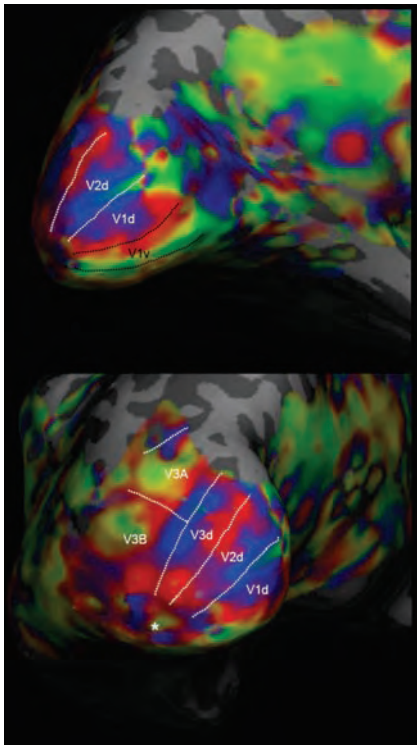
Visual cortex consists of V1-V5/MT with V1 (striate cortex) situated in the posterior pole of the occipital lobe. Shown are computationally inflated anatomical MRI scans (where gyri are light gray and sulci dark gray) of the occipital lobe on which have been superimposed functional MRI data, coloured to represent the retinotopic region of the visual field to which these areas respond. This is used to delineate the borders of retinotopic visual cortices, shown by dotted lines and labelled (the foveal representation is indicated by a star). Extrastriate retinotopic areas comprise dorsal ('d') and ventral ('v') regions representing the lower and upper visual fields respectively. Damage to the inferior division of the middle cerebral artery supplying lateral parietal and superior temporal cortices, as well as posterior cerebral artery damage supplying inferior temporal and occipital lobe, can result in prominent homonymous hemianopia.
